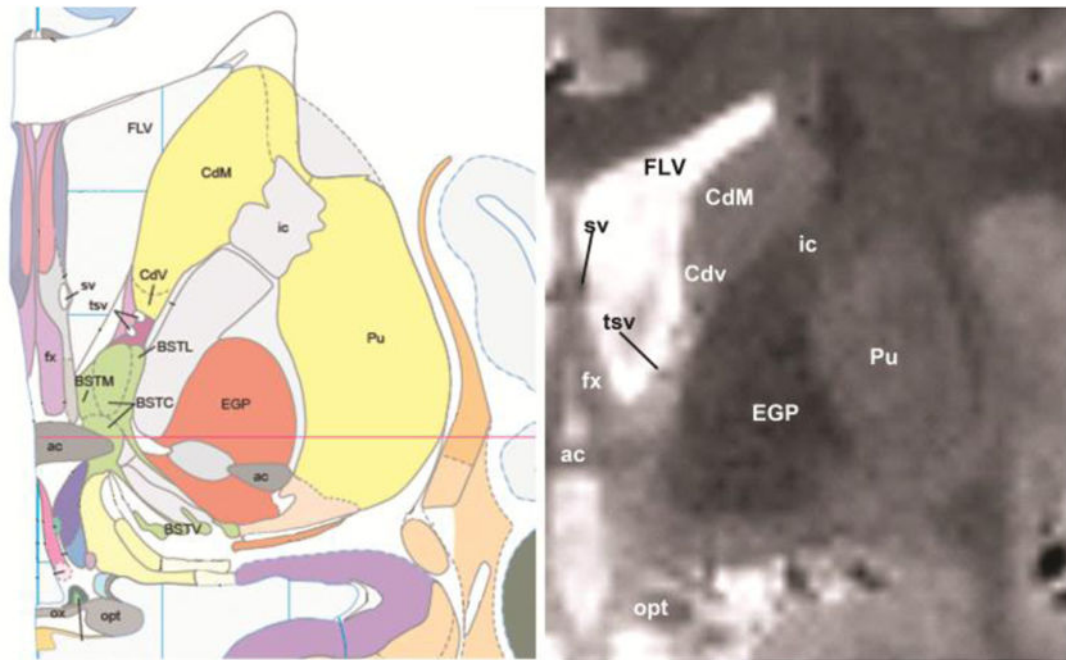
Structural MRI scan of the human BNST
